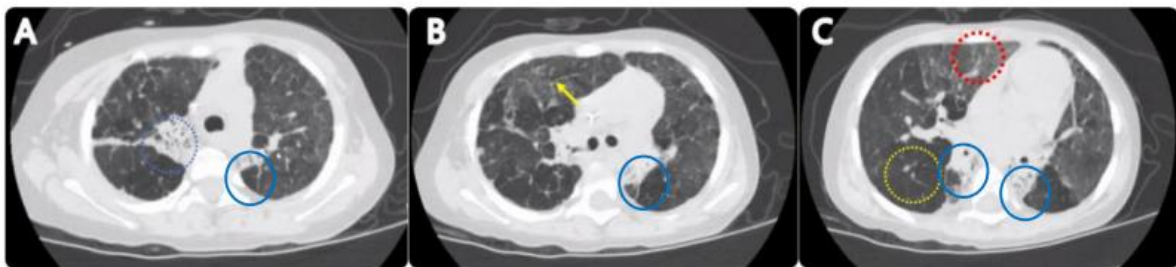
CT scan after 19months of discharge showing mosaic attenuation pattern, (hyperinflation (yellow circle) and ground glass opacity (red circle)), atelectasis (blue circle), and interlobular septal thickening (yellow arrow) in both lungs.
